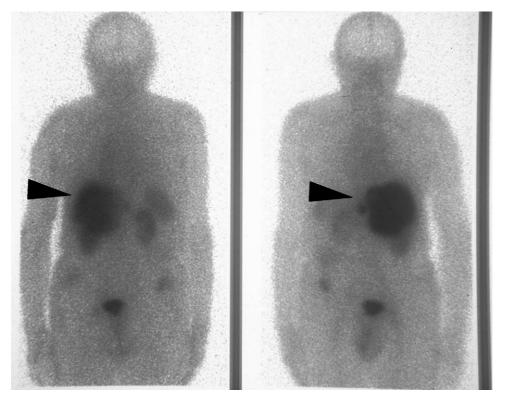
¹¹¹In–DTPA–pentetreotide whole body scintigraphy (Octreoscan) showing an elective uptake of the radiolabeled octreotide in the liver, expression of distant localization of the neuroendocrine tumor of the lung (arrow).
